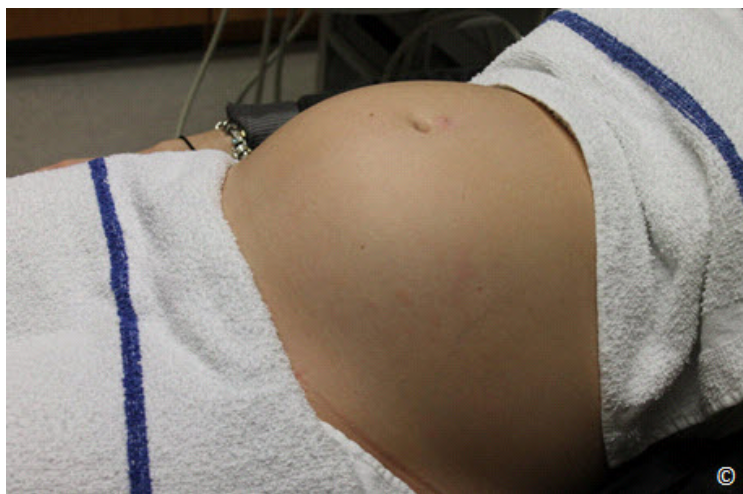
Patient preparation for an ultrasound examination. Note the placement of towels to protect the patient's clothes and for modesty.
